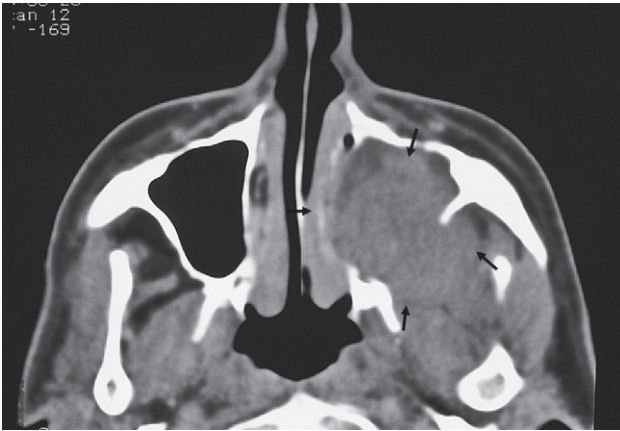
Carcinoma of the antrum. CT scan showing a large mass arising from the left antrum destroying its bony walls and extending into the adjacent soft tissues. The arrows point to the extent of the tumour. The opposite antrum is normal.
